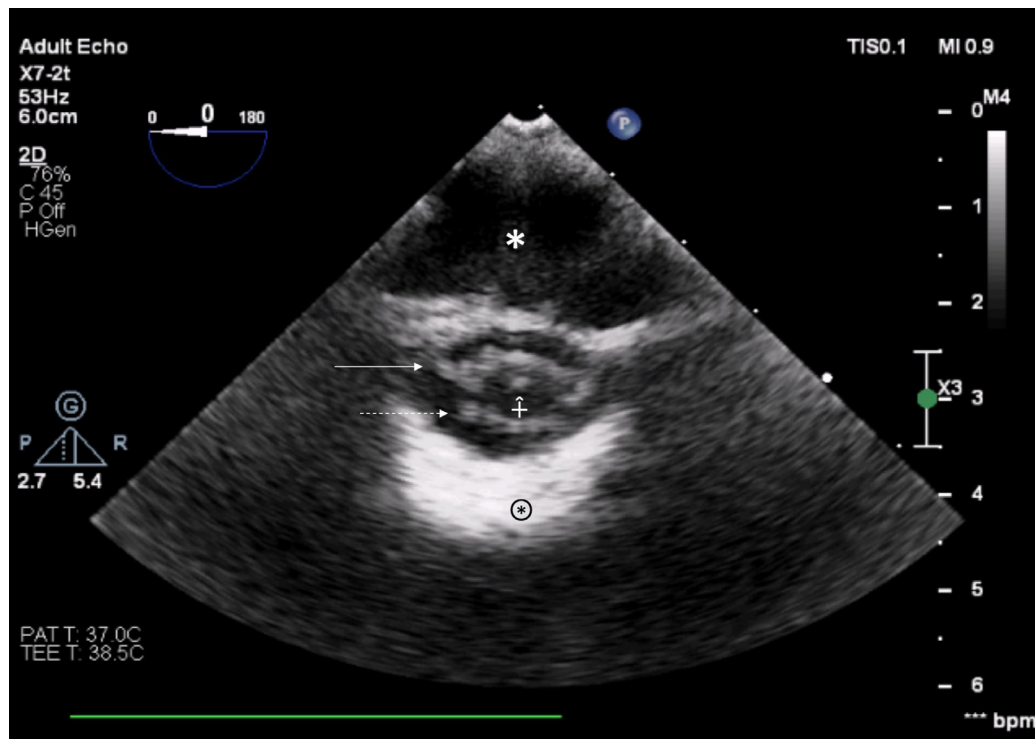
Transesophageal echocardiographic short-axis view of the thoracic spinal canal, showing the intervertebral disc (*) with posterior acoustic enhancement (⊗); the spinal cord (+) with central canal (^); anterior nerve roots (solid arrows); posterior nerve roots (dashed arrows); and the surrounding anechoic cerebrospinal fluid
